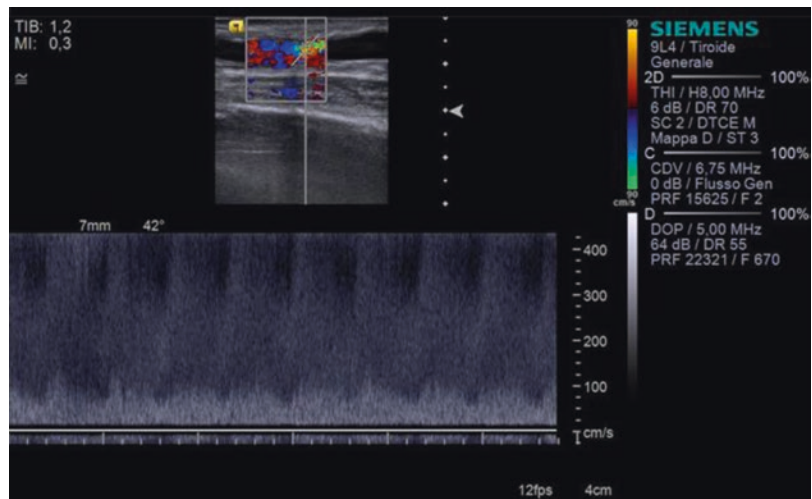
Stenotic complication of AVF venous outflow. Doppler examination should always be performed with a beam-steering transducer to maintain the correct angle of incidence (30°–60°) relative to the direction of flow. Right
